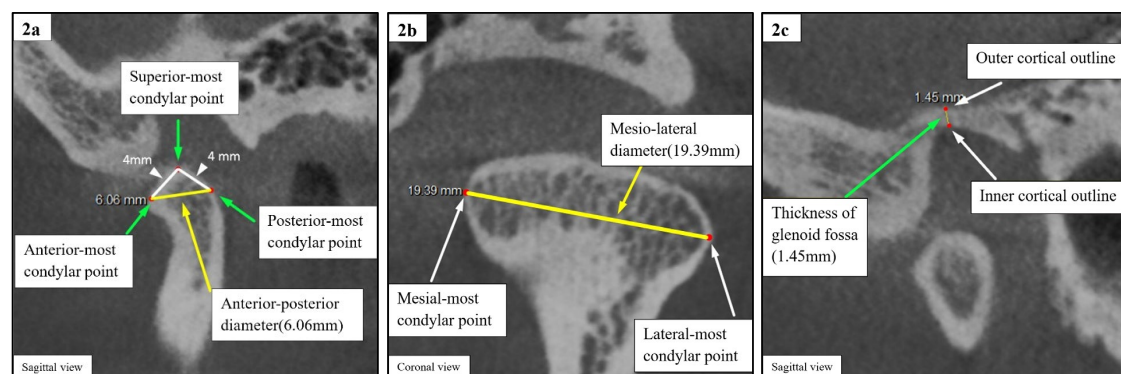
CBCT image showing how the measurements were done: a) The anteroposterior diameter of the condyle, b) The mesiodistal diameter, c) The thickness of the glenoid fossa
